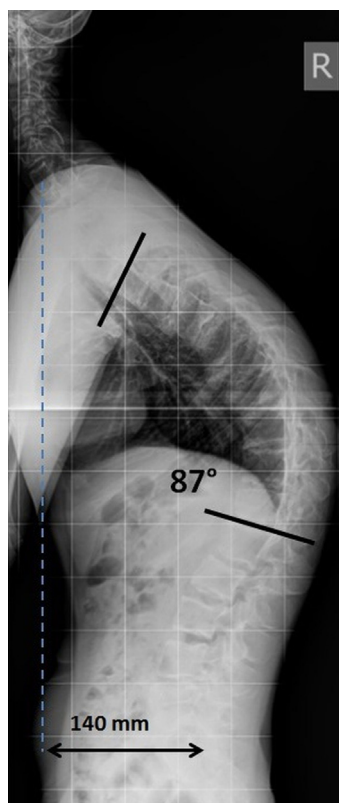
Preoperative sagittal radiograph showing thoracic hyperkyphosis of 87° and sagittal vertical axis of 140 mm.
